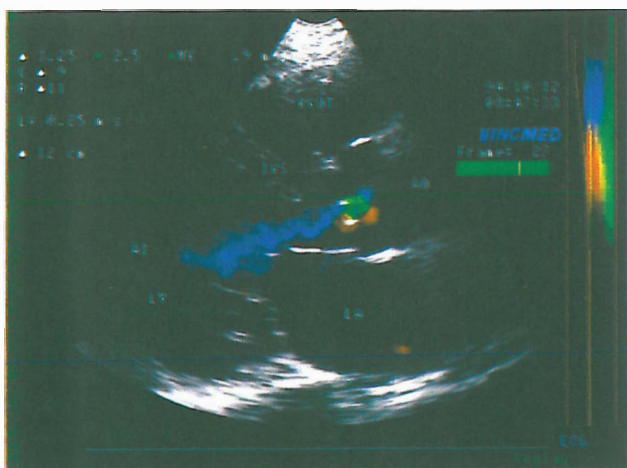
Parasternal long-axis view; arrow denotes AI.
